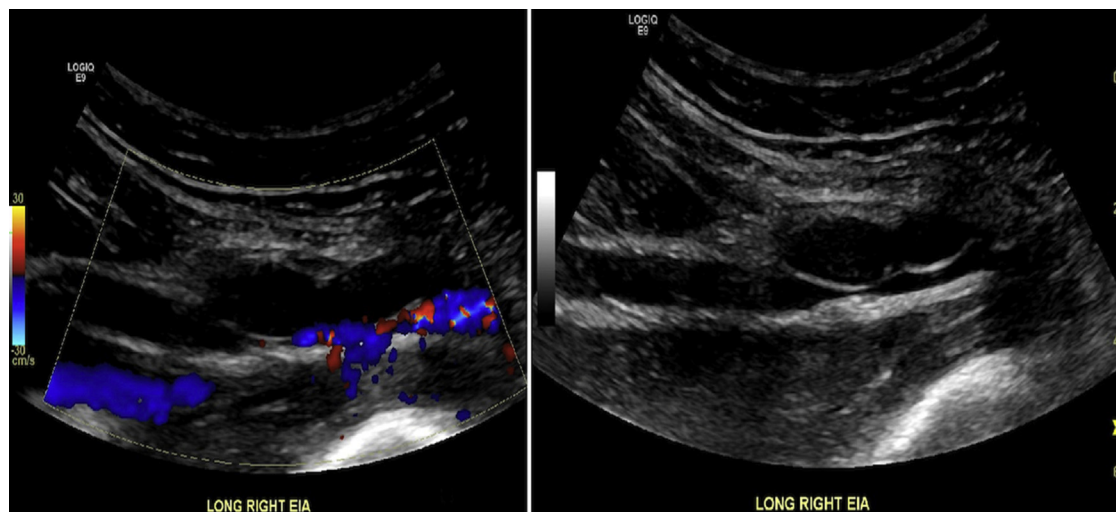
Iliac arterial ultrasound scan in duplex mode (*Left*) and B-mode (*Right*).
